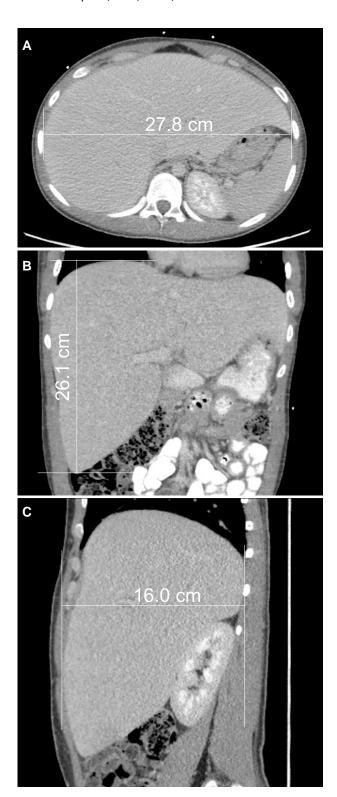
Measurement of liver dimensions based on the abdominal computed tomography sectional images in medial-lateral (A), cranio-caudal (B), and anterior-posterior (C) direction.
